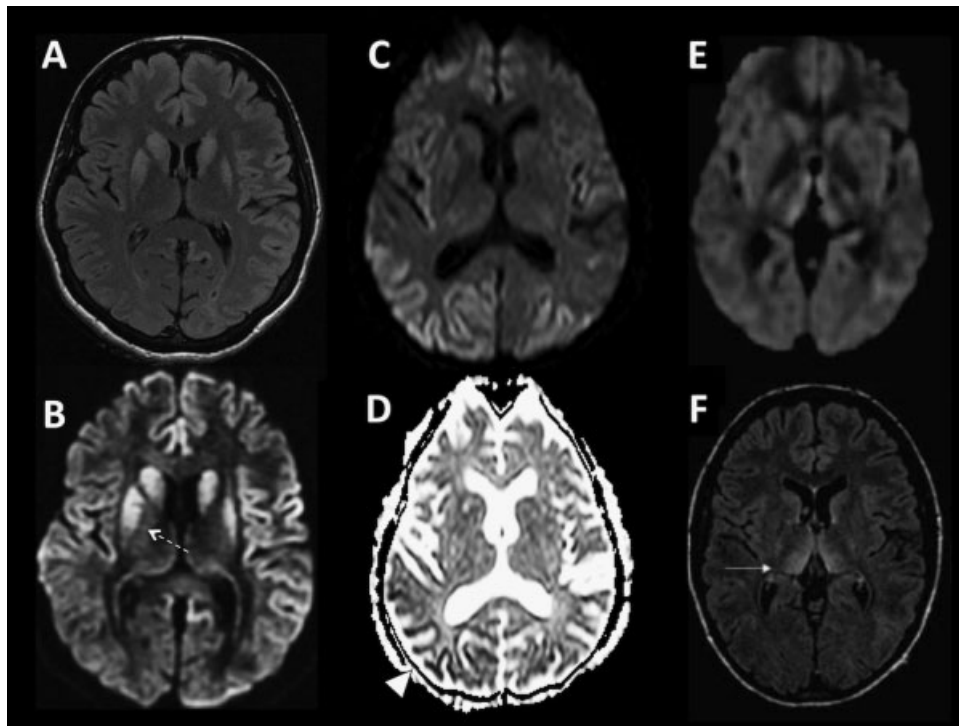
Brain magnetic resonance imaging (MRI) in sporadic Jakob-Creutzfeldt disease (sjCD). (A,B) Axial brain MRI in a patient with JCD. (A) Fluid attenuated inversion recovery (FLAIR) sequence showing bilateral striatal hyperintensities and cortical hyperintensities in the bilateral medial frontal regions, left posterior frontal, and anterior parietal regions. Posterior cingulate cortex is also hyperintense. (B) Diffusion weighted image (DWI) showing cortical ribboning in the same regions as FLAIR sequence, and also in the right peri-insular cortex. Striatal hyperintensities are also present. Note the anterior-posterior gradient in striatum (*dotted arrow*). (C,D) Axial brain MRI in a patient with sjCD. (C) Axial DWI showing cortical ribboning in parietal, occipital and frontal regions (right more than left). Caudate and putamen are mildly hyperintense, more on the right side. (D) Apparent diffusion coefficient map showing bilateral hypointensities in parietal (*arrowhead*) and occipital cortices (right more than left). (E,F) Probable variant JCD with MRI showing bilateral thalamic hyperintensity in the mesial pars (mainly dorsomedian nucleus) and posterior pars (pulvinar) of the thalamus, the so-called double hockey stick sign. Also note the “pulvinar sign” (*solid arrow*), with the posterior thalamus (pulvinar) being more hyperintense than the anterior putamen. (Modified from Vitali et al. *Semin Neurol* 2008;28(4): 467–483).
